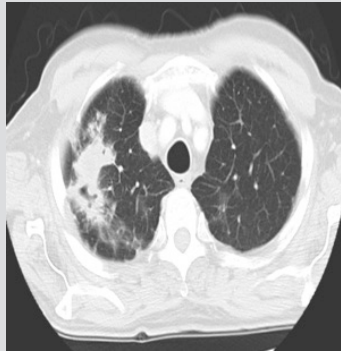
CT of the chest showing nocardial focus.
